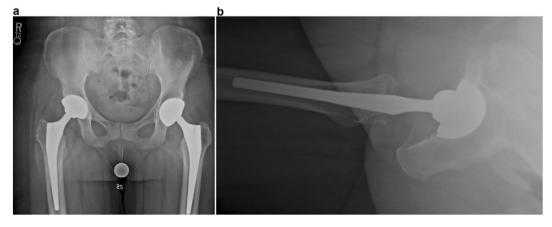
Prerevision surgery (a) anteroposterior and (b) lateral radiographs of the right hip without evidence of significant component compromise or loosening.
